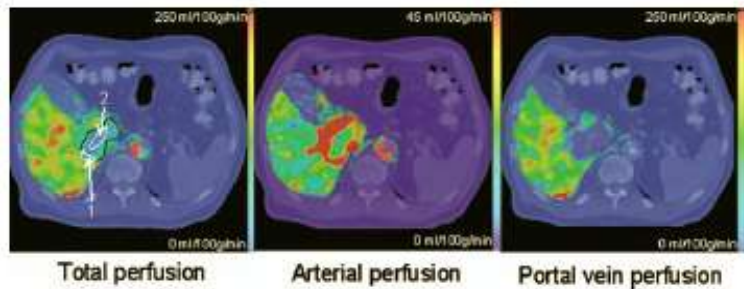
Dynamic Contrast-Enhanced images. Color-coded perfusion maps overlaid on corresponding CT images to denote spatial variation in perfusion. The black contour outlines the tumor region, while the white contours outline regions of interest to be quantified using post-processing techniques [35].
